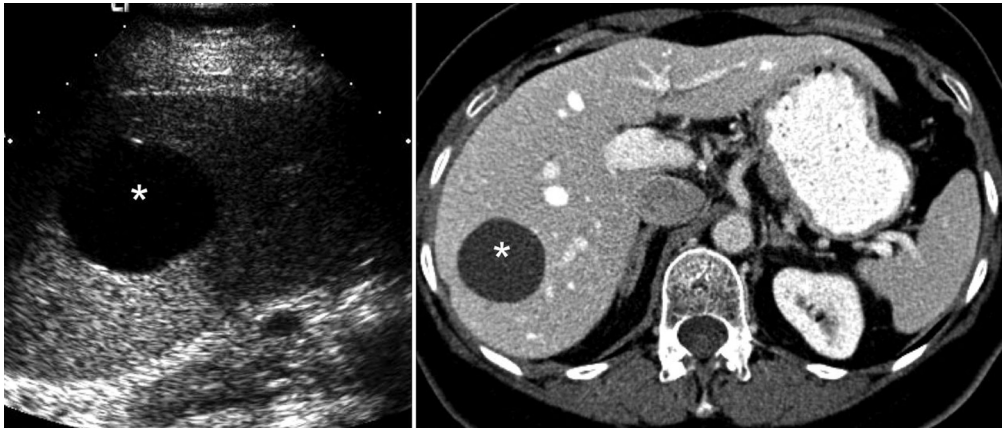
Ultrasound (*left panel*) and contrast-enhanced CT (*right panel*) of liver showing a simple cyst (*asterisk*).
